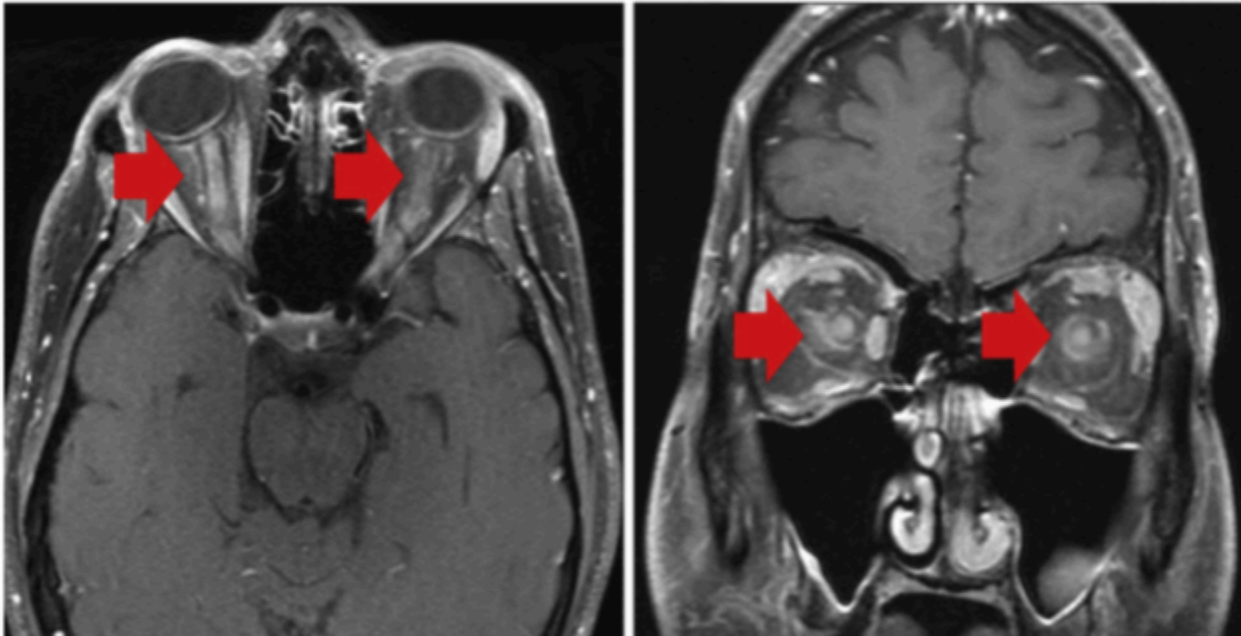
MRI with contrast: Bilateral prominent enhancement of optic nerve and sheath (perineural enhancement), extending along almost the entire nerve (red arrows) (40).
